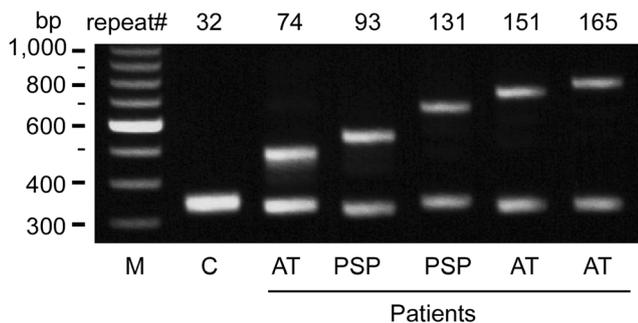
The result of agarose gel electrophoretic analysis for the *ATXN8OS* gene in our patient. Five patients had expansions of CTA/CTG repeat as indicated, while control (C) had a normal repeat size. AT ataxia, PSP progressive supranuclear palsy, M 100 base pair (bp) marker
